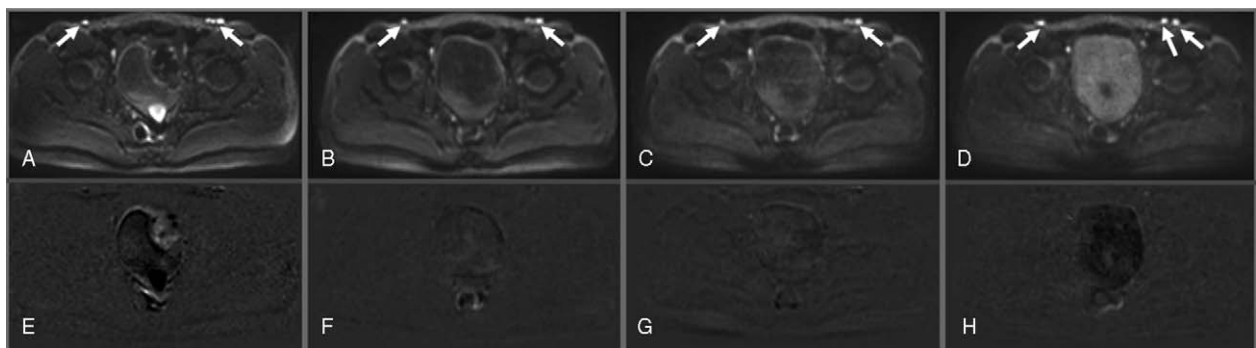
Exemplary diffusion-weighted images with b -value of $800\text{ s}^2/\text{mm}^2$. Two lymph nodes (arrows) in the abdominopelvic region are depicted. The upper row (A–D) shows different acceleration factors applied on the SMS-DWI. A: Conventional DWI; B: AF2; C: AF3; D: AF3 with higher slice resolution. The lower row (E–H) shows the corresponding subtraction dataset for the conventional (E) and each accelerated (F–H) DWI sequence used for measuring image noise and SNR calculation. DWI= diffusion weighted sequences, SMS=simultaneous multislice, SNR=signal to noise ratio.
